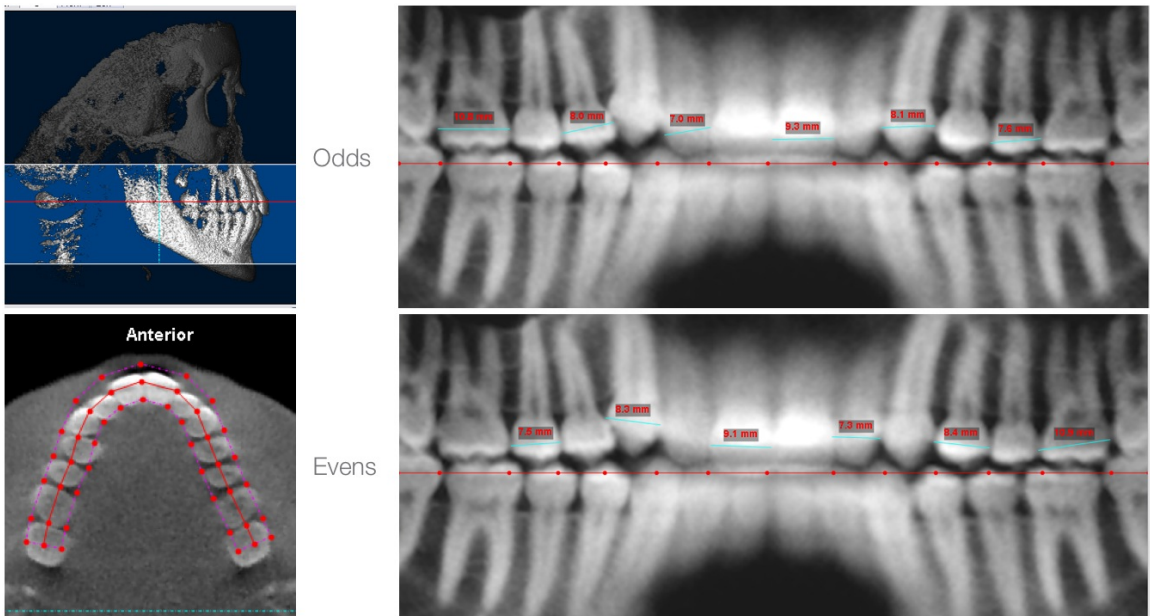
Method 3: CBCT Detailed Pano - Dolphin (Maxilla).
